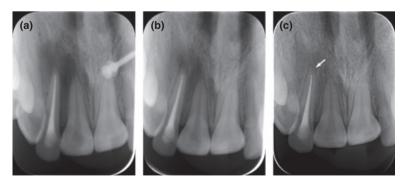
3 (a), 6 (b) and 10-month (c) follow-up radiographs. Arrow showing the cementum deposits.
